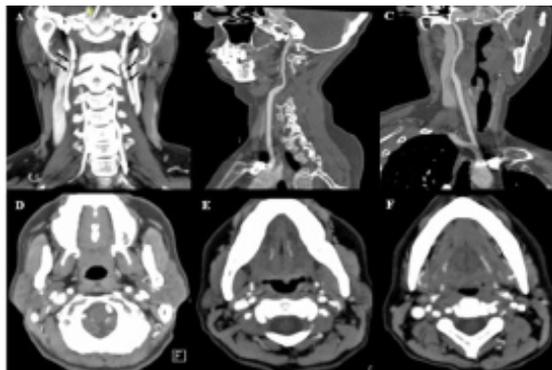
Neuroimaging workup with clear FD findings without evidence of carotid artery dissection. Legends: Coronal (A) and sagittal (B, C) cervical CT-angiogram in maximal intensity projection (MIP) demonstrating carotids with multiple saccular dilations and stenosing webs (black arrows). This finding is compatible with the classical “strings of beads” sign. There is no evidence of carotid artery dissection (D-F).
